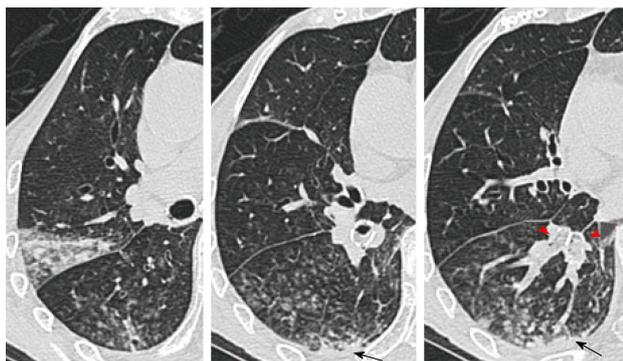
Aspiration pneumonia in a woman in her 70s (causative pathogen unknown). Thin-section computed tomography images show centrilobular nodules with surrounding ground-glass opacities and subpleural non-segmental consolidations (arrows) at the dorsal portions of the right lung. Note that the lumens of segmental bronchi are filled with aspirated materials (arrow heads).
